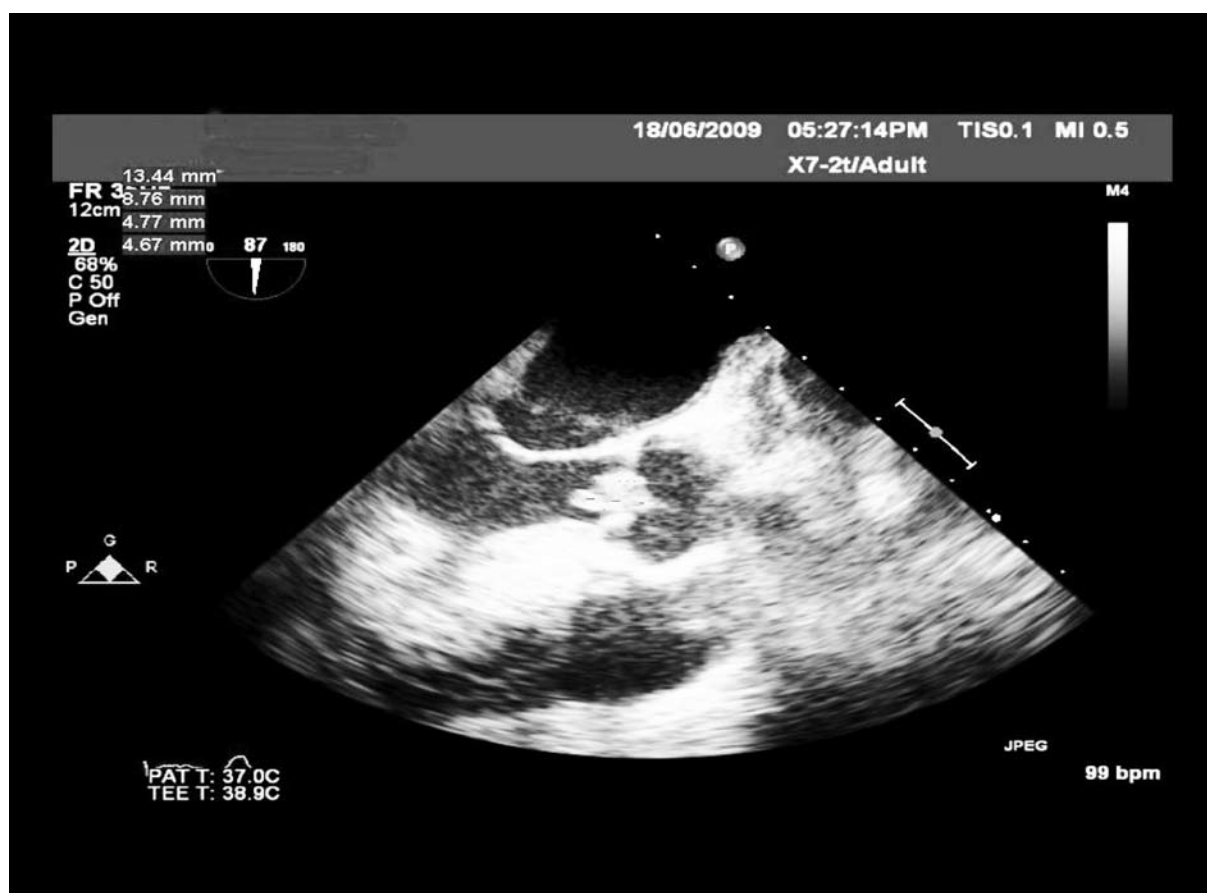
2-D echocardiography of the heart showing large vegetations on the aortic valves.
